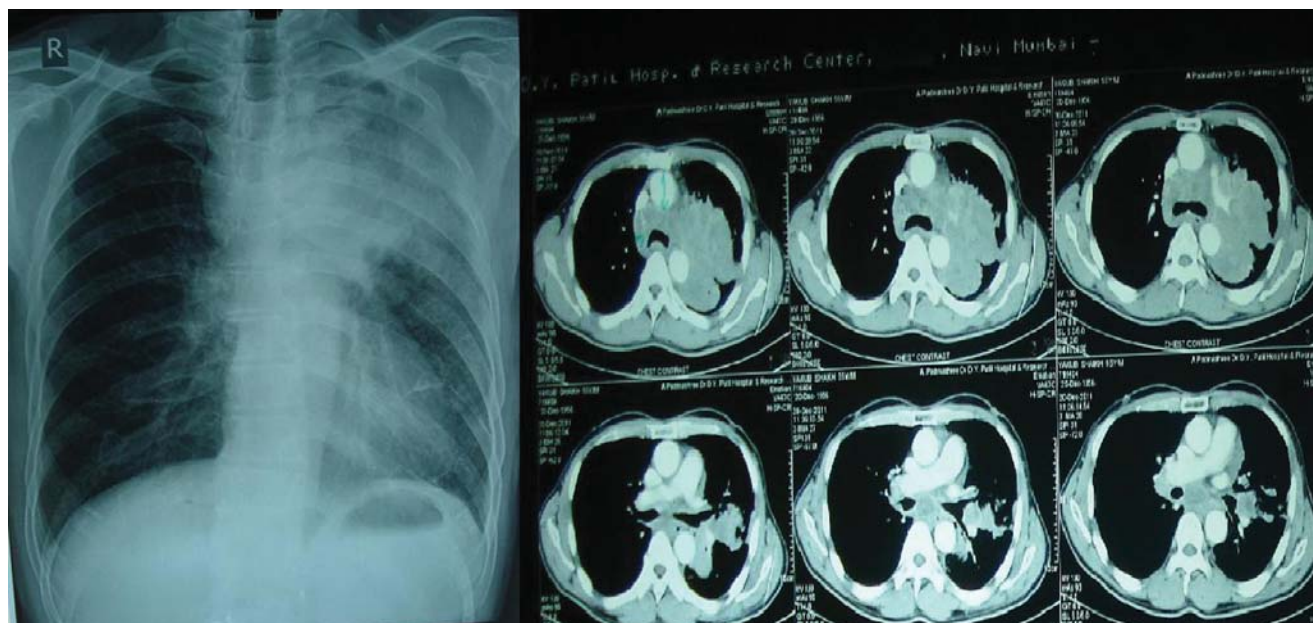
Chest X-ray and CT scan of a patient with bronchogenic (small-cell) carcinoma.
